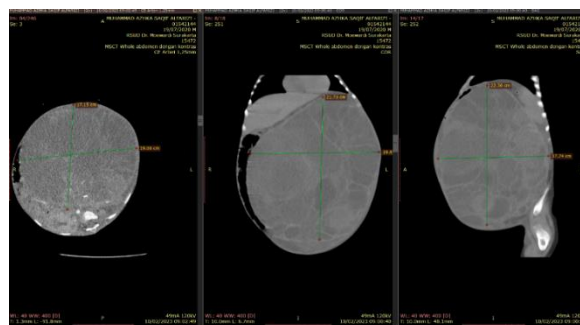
CONTRAST ABDOMINAL CT SHOWED A SOLID MASS IN THE LEFT KIDNEY WITH A SIZE OF 22.36 X 19.66 X 17.12 CM.
